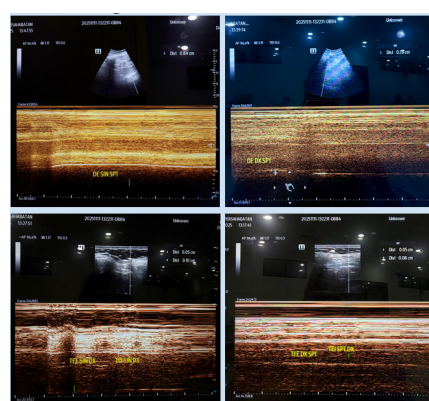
Case II: Diaphragm ultrasonography showing dysfunction and atrophy (11/11/25)
